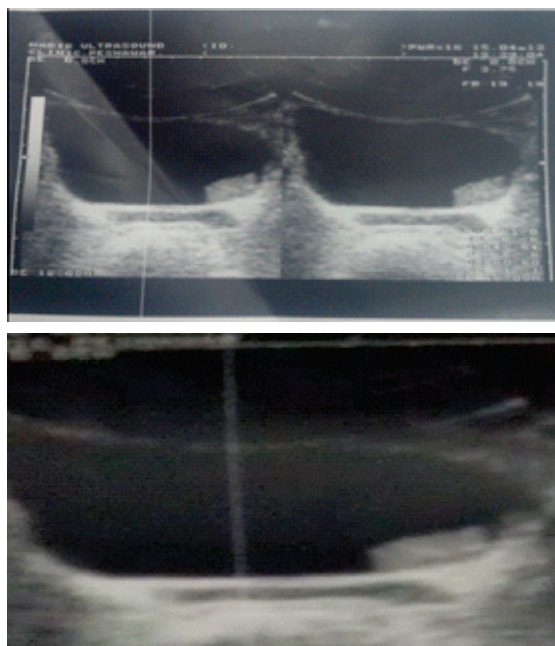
& 2 showing urinary bladder growths on ultrasound pelvis of the patients.
